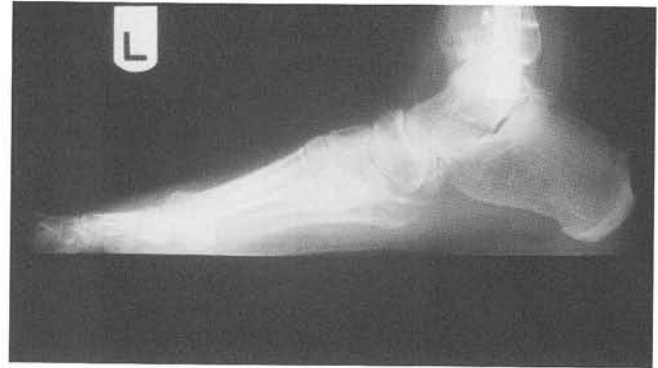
Preoperative lateral weightbearing bilateral radiograph.
